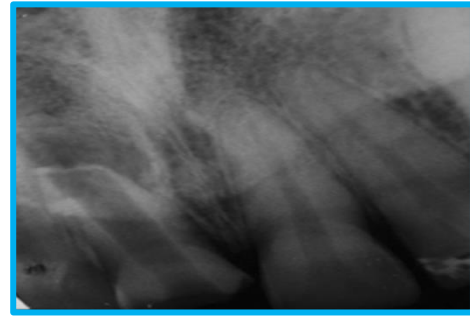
Radiograph of A Non Vital Tooth (11)
